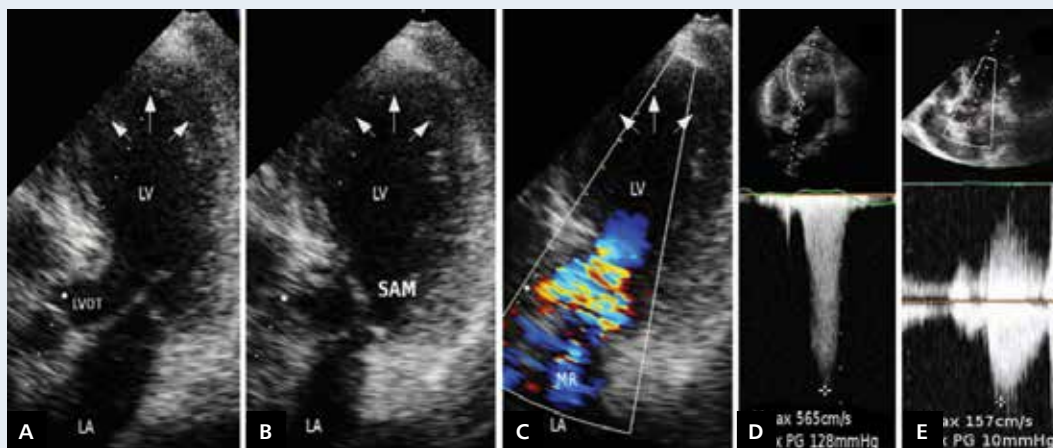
Transthoracic echocardiography. Apical five-chamber view showing: apical ballooning (A–C), hyper-contraction of left ventricular outflow track (LVOT) with systolic anterior motion (SAM) of anterior mitral leaflet (B) that resulted in mitral regurgitation (MR) (C) and significant gradient in LVOT of 128 mm Hg (D). The control examination (E) showing only mild MR but neither SAM nor dynamic LVOT obstruction (with LVOT-gradient of 10 mm Hg); LA — left atrium; LV — left ventricle
